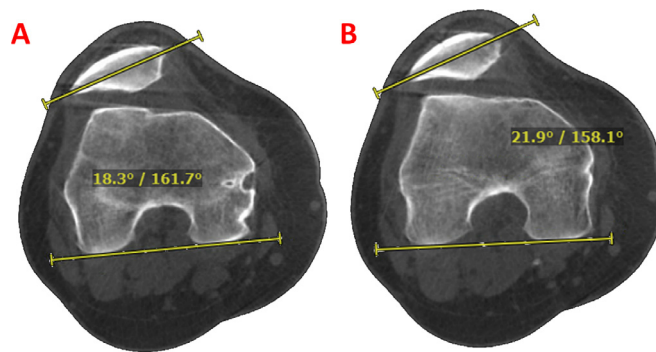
Established 2D Patellar Tilt Measurement – (A + B) Patellar tilt measurement according to Dejour [2] for the same knee and scan, measured on different slices of the CT scan, resulting in different values for the patellar tilt angle.
